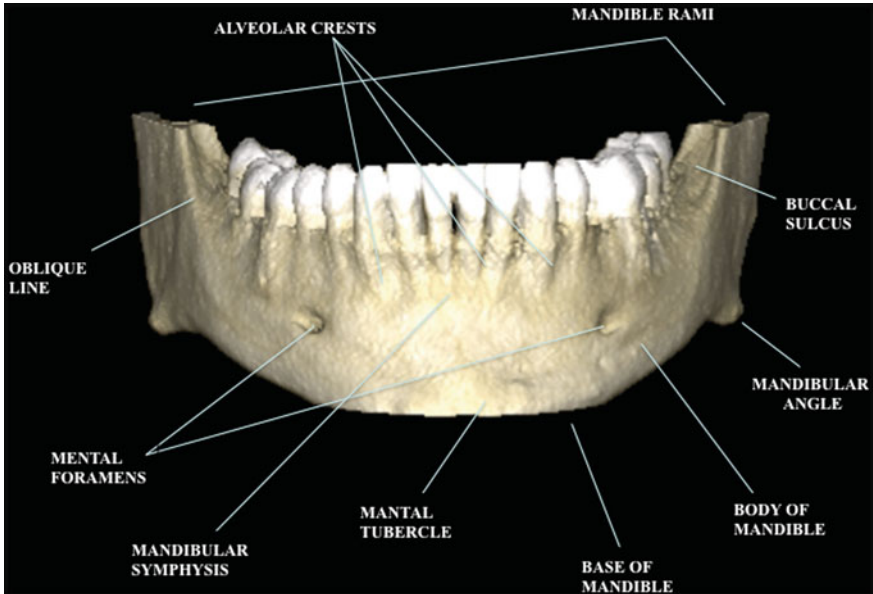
Mandible, CBCT-3D reconstruction; outer surface, anterior view
